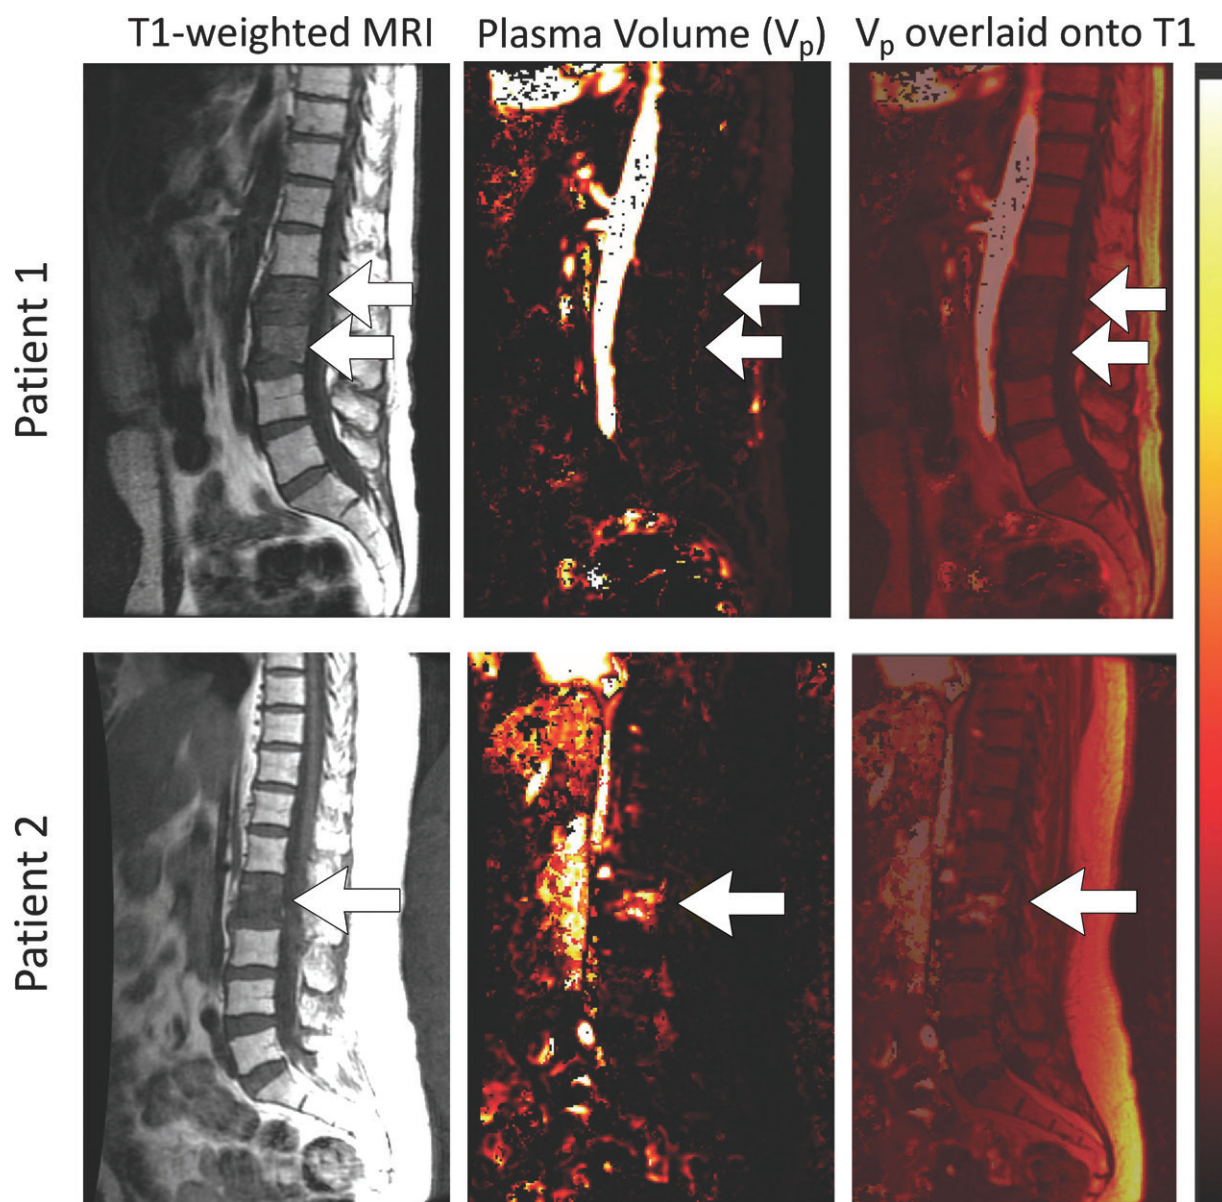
Example of two patients with colon cancer. The left column shows sagittal T1-weighted MRI of the lower spine. Hypointense regions indicate vertebral lesions. Arrows point to biopsy-verified vertebrae of interest. In the top row, patient 1 had biopsied spinal lesion reported by pathology as no evidence of malignancy at L2–3 (left column). In the bottom row, patient 2 had malignant lesions at L2. The middle column shows fractional plasma volume (V_p) maps of the lesions. Increased signal intensity was observed in malignant lesions. The V_p for patient 1 was 0.9, for patient 2 the V_p was 5.8. The right column shows merged T1-weighted MRI and dynamic contrast agent-enhanced perfusion MRI V_p map.
